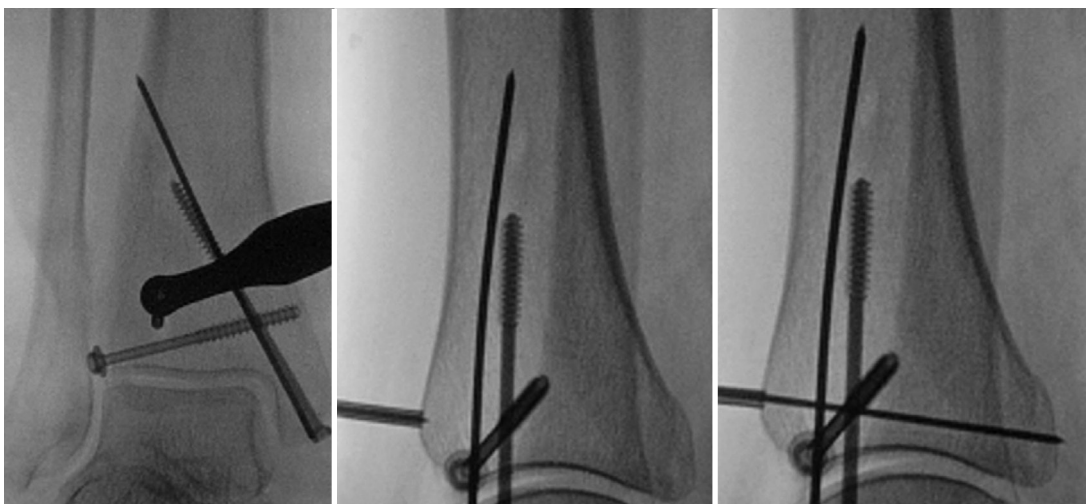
Left and center images: mortise and lateral radiographs showing the K-wire starting point. Right image: lateral radiograph showing the K-wire reaching the posterior cortex of the posterior malleolar fracture.
